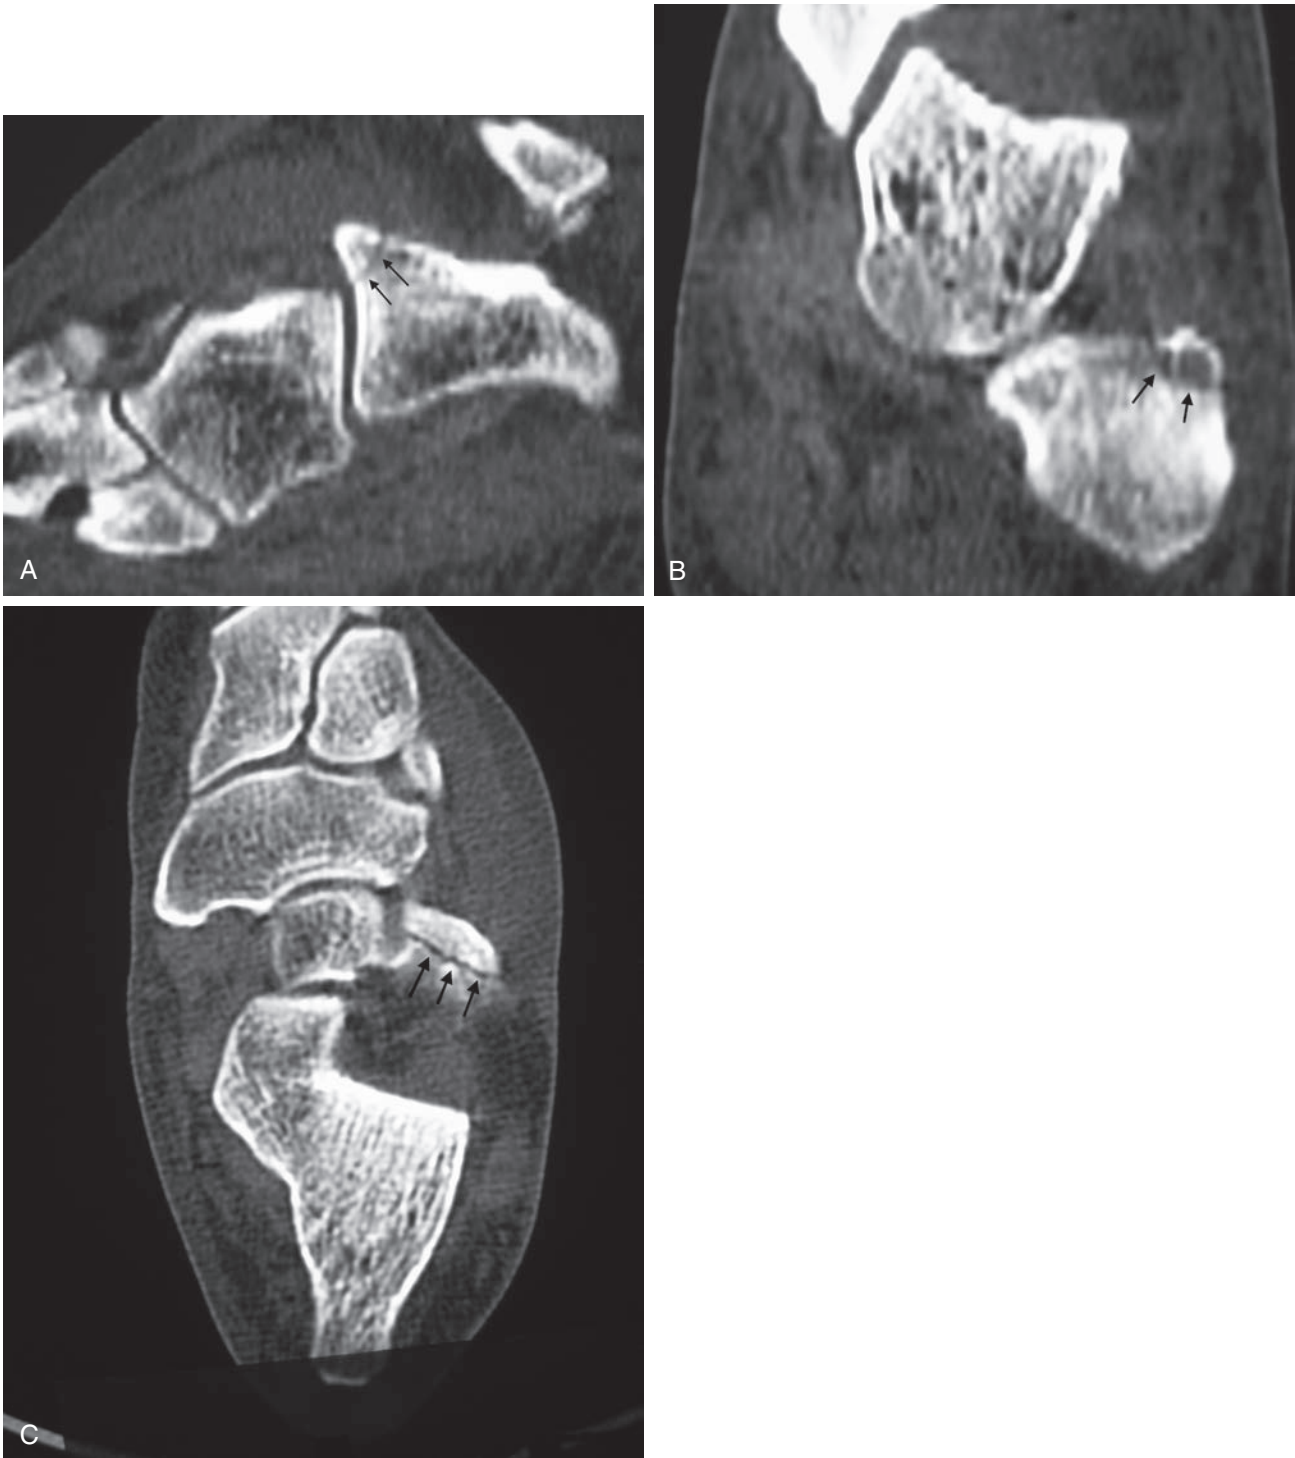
(A) Sagittal reconstruction, (B) coronal, and (C) axial computed tomography view of occult anterior process fracture (*arrows*) of calcaneus. Plain radiographs did not reveal fracture, but athlete had tenderness over anterior process.
